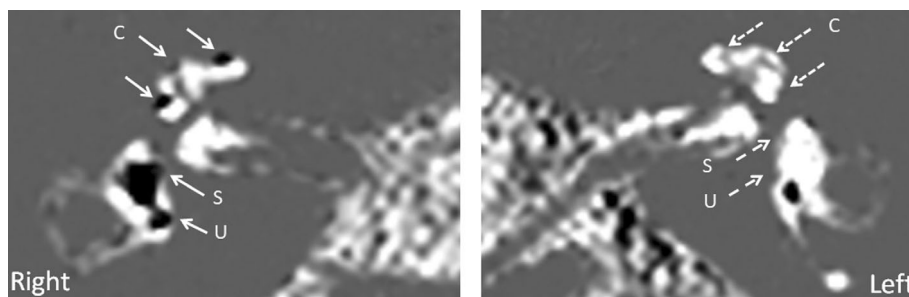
A 68 years old man with MD on the right ear with four-tone average of 37 dB (stage II). Hydrops MRI demonstrates Grade II hydrops at the cochlea (C), saccule (S) and utricle (U) of the right ear. Left ear, control. Solid arrows: present hydrops; dashed arrows: no hydrops.
